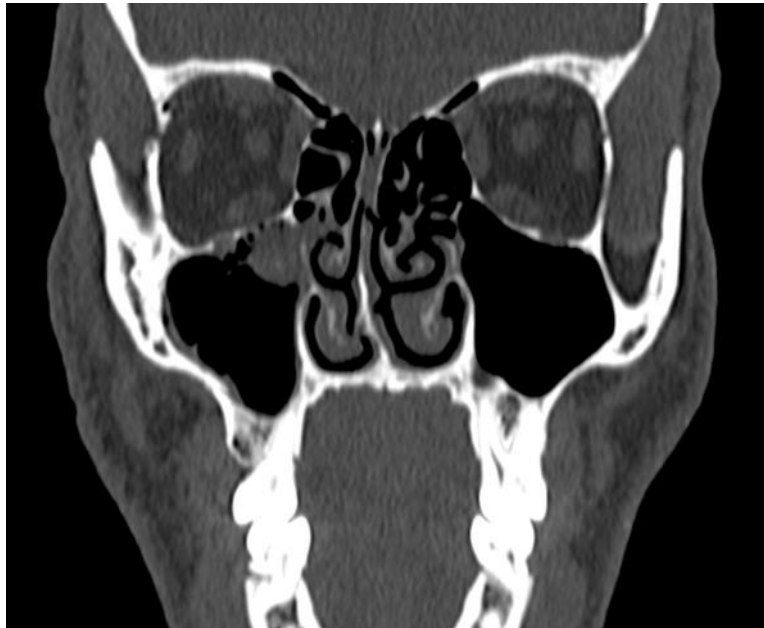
Coronal CT image of the face reveals a fracture of the lateral wall of the right orbit.
